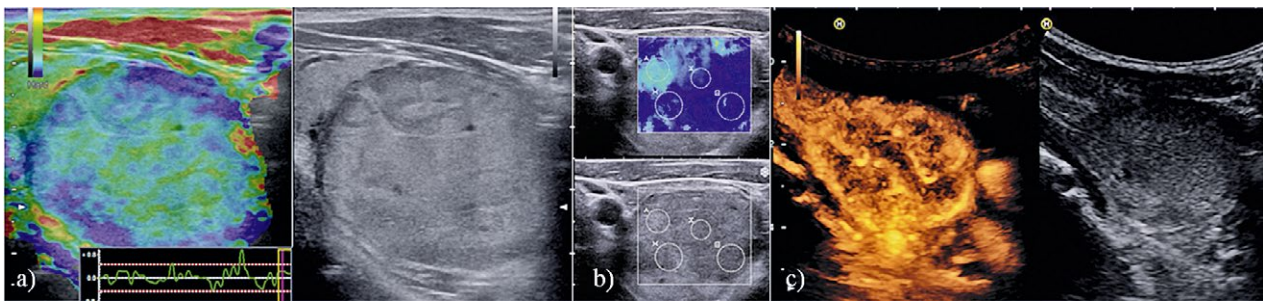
Multinodular goiter in a 55 year old male. The nodule is displayed using different elastographic techniques (a-b) and contrast enhanced ultrasound: a) shows the architecture using quasi static strain elastography technique and b) displays the measurement values using shear wave elastography. Primarily a neoplastic lesion was suspected and surgery performed. Comparative data between different manufacturers are not published so far. Contrast enhanced ultrasound revealed inhomogenous enhancement due to regressive changes (c).
